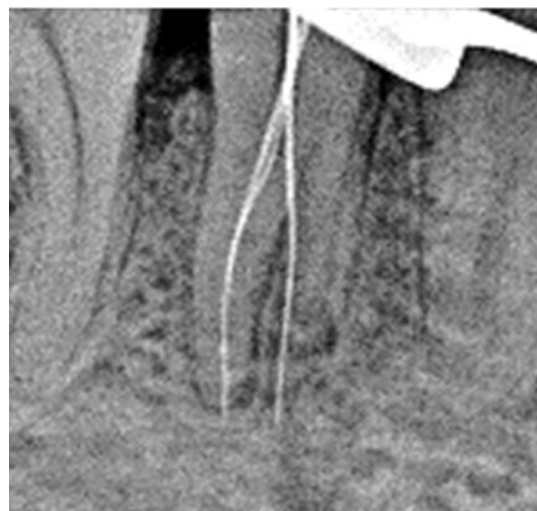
Working Length radiograph with ISO 15# K files placed in the canals (45) (Vertucci Type IV).
